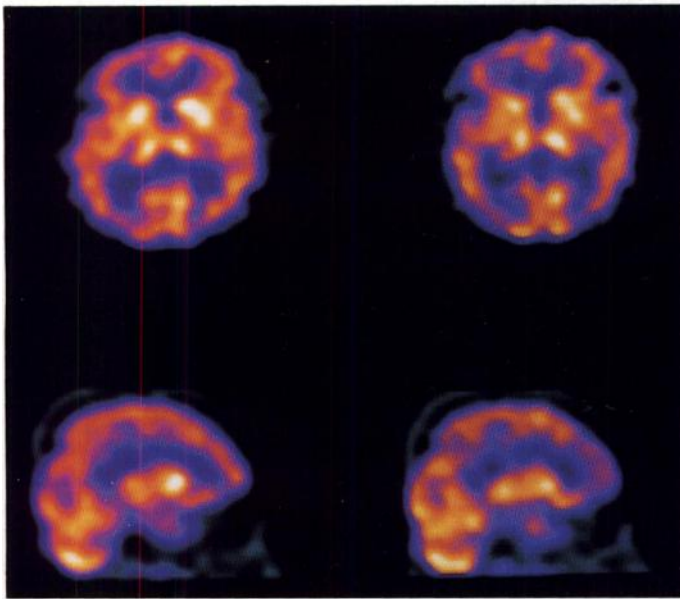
Technetium-99m-HMPAO SPECT images of a 53-yr-old patient with CABG. Axial (top) and sagittal (bottom) images. Left column before surgery and right column after surgery. Frontal hypoperfusion is seen after surgery.
